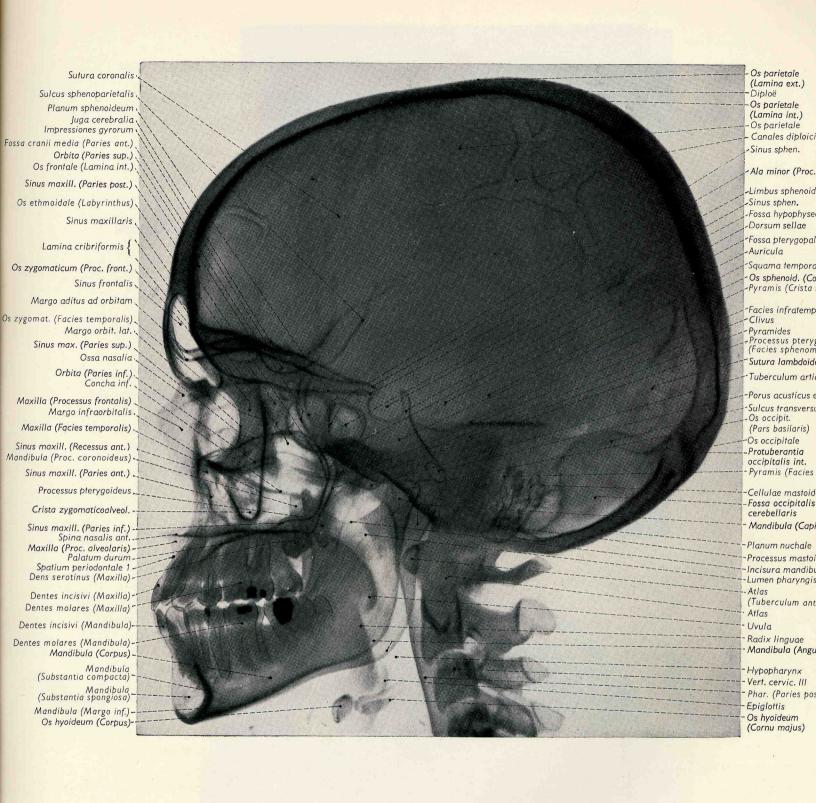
Lateral roentgenogram of adult human skull (from Clementschitsch).
